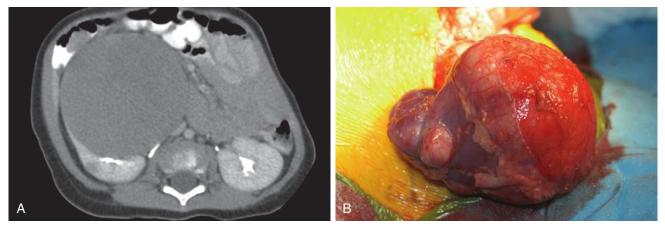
A, Abdominal CT scan of Wilms tumor shows a bulky mass to the right of midline. B, Intraoperative Wilms tumor with a large tumor mass involving the kidney.
